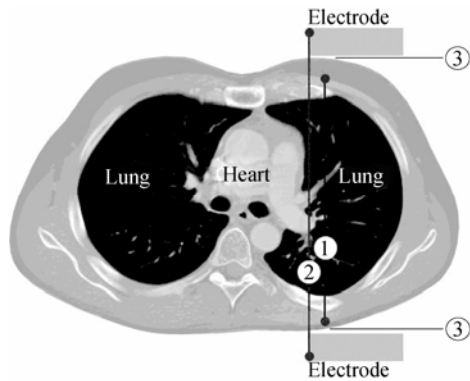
The structure of transthoracic impedance. 1: Internal thoracic impedance, 50–80 Ohm; 2: Transthoracic impedance, 1050–1280 Ohm; 3: Each skin-electrode impedance, 500–600 Ohm.
